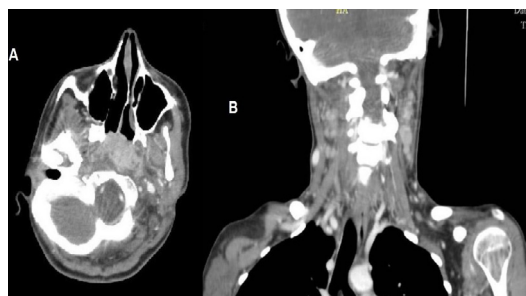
A) Axial View of Neck CT-scan with IV Contrast Showing a Large Nasopharyngeal Enhancing Mass; B) Coronal View of Neck CT-scan with IV Contrast Showing a Nasopharyngeal Mass with Several Enlarged Lymph Nodes.
